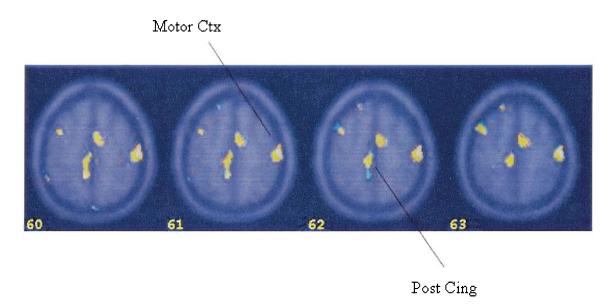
Statistical parametric map overlaid on a magnetic resonance imaging template of areas of significant activation (in yellow) during retrieval of emotionally valenced words in women with childhood sexual abuse and posttraumatic stress disorder (PTSD) (n = 10) and women without childhood sexual abuse or PTSD (n = 11). There were significant increases in blood flow during retrieval of emotionally valenced word pairs in PTSD relative to non-PTSD in motor cortex, visual association cortex (Brodmann's Area [BA] 19), cerebellum, left inferior parietal lobule (BA 40), and right middle temporal gyrus (BA 20). Ctx, cortex; Cing, cingulate.
